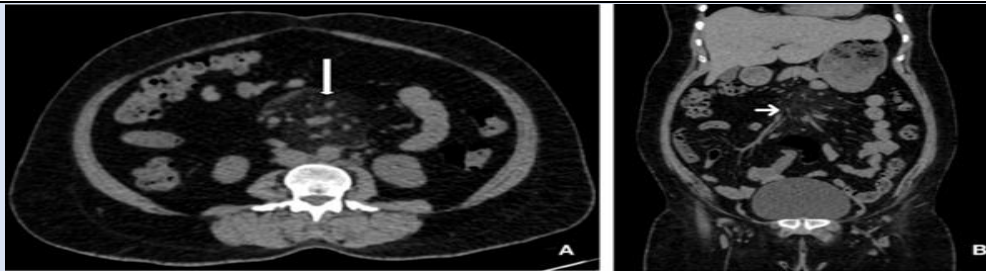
(A and B) Mesenteric panniculitis in a 42-year-old female patient. CT abdomen plain axial (13A) and coronal (13B) section images showing inflammatory fat stranding around the mesenteric vessels displacing the bowel loops but not displacing the mesenteric vessels.
